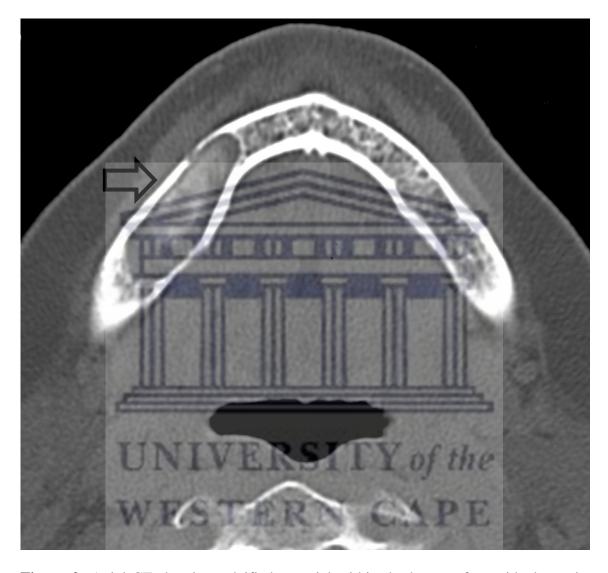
Axial CT showing calcified material within the lumen of a residual cyst in right mandible.
